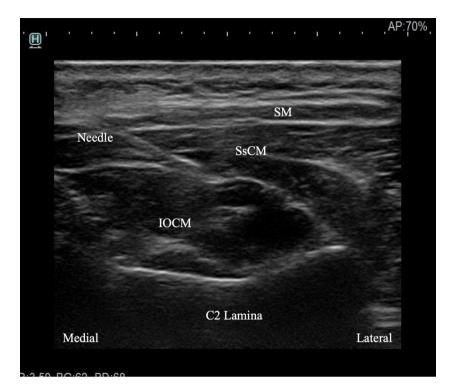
Ultrasound guided greater occipital nerve (GON) block
